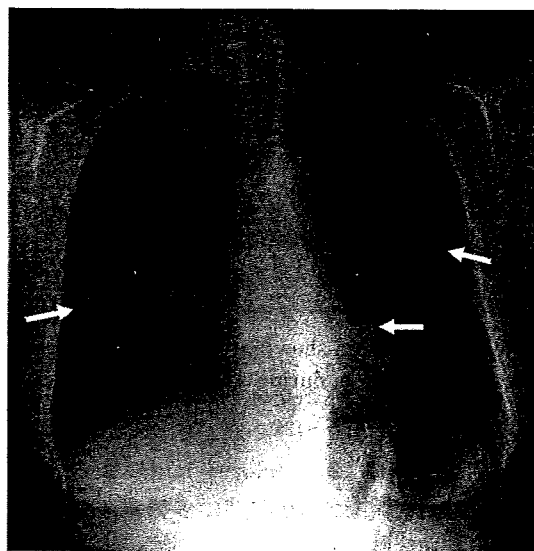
Chest X-ray on admission showing multiple nodules in bilateral lung fields.
